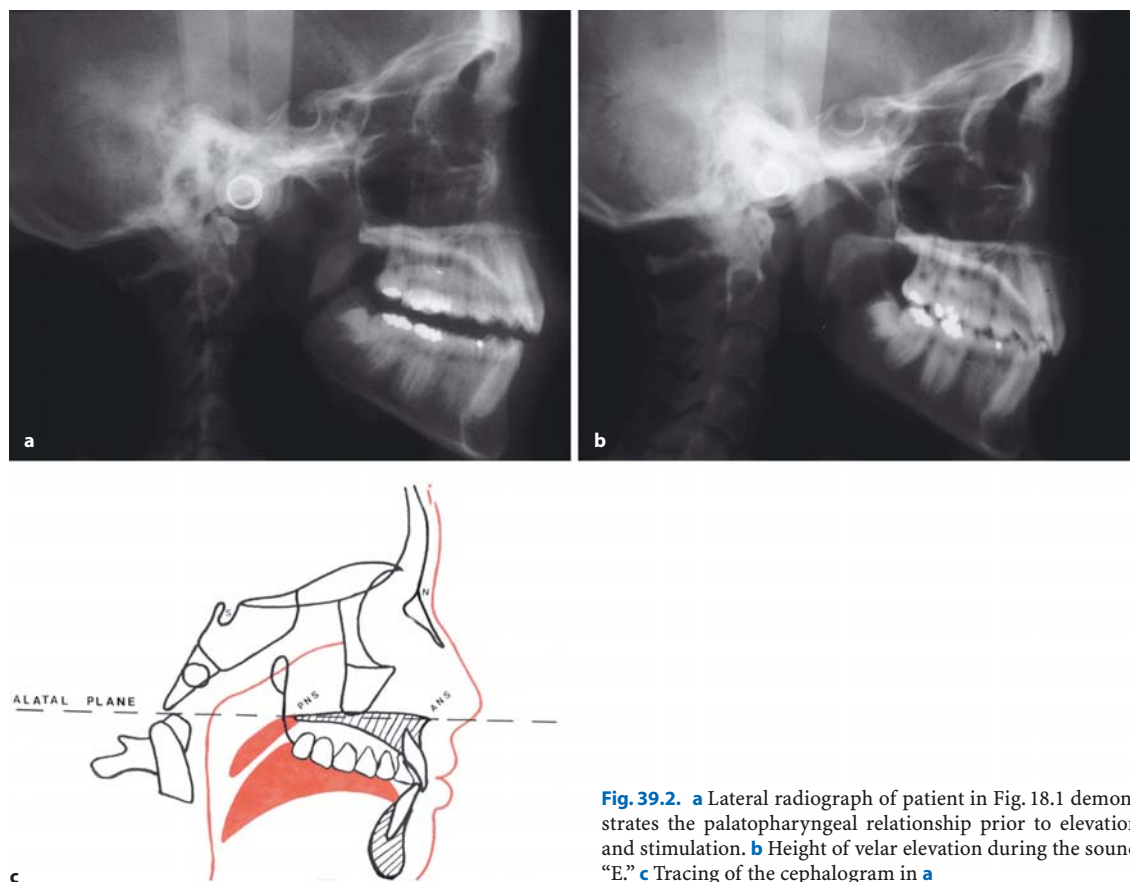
a Lateral radiograph of patient in Fig. 18.1 demonstrates the palatopharyngeal relationship prior to elevation and stimulation. b Height of velar elevation during the sound "E." c Tracing of the cephalogram in a
